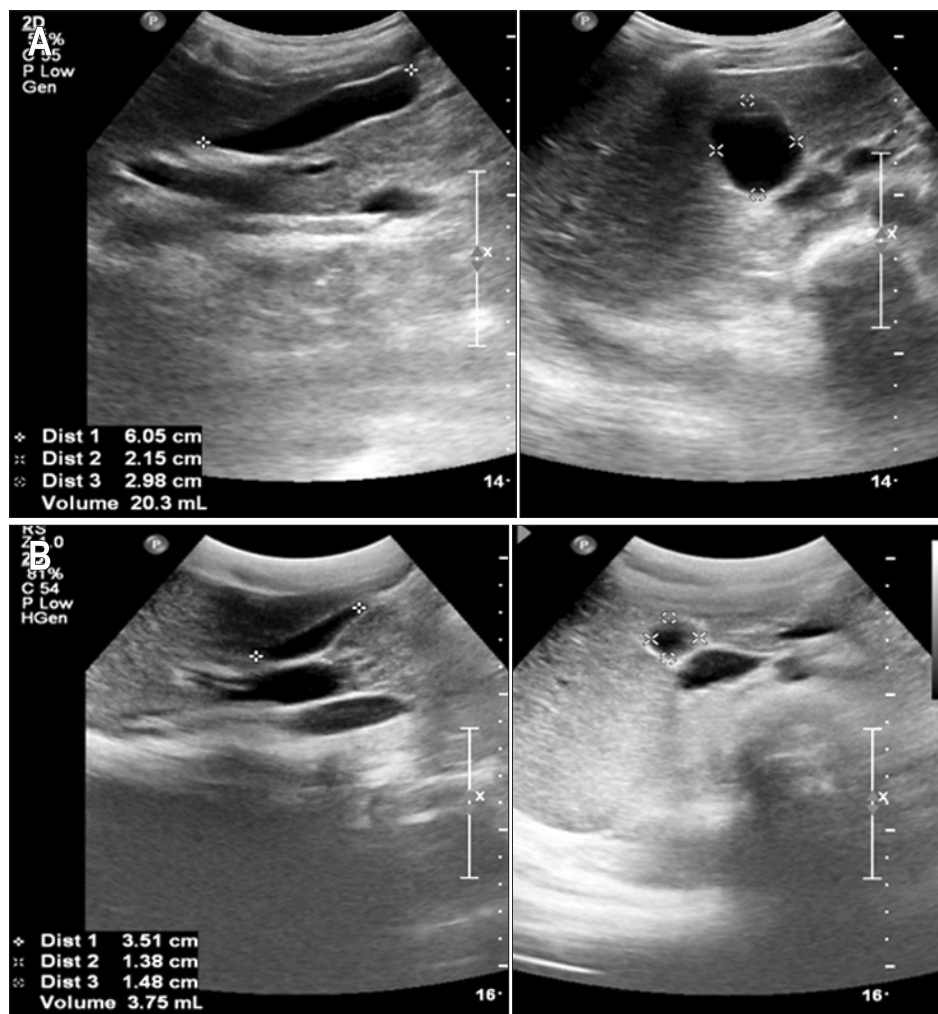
Ultrasound evaluation of gallbladder volume using Dodd's formula in the preprandial (A) and postprandial (B) states in a control child. Distances 1, 2, and 3 represent gallbladder length, width, and height, respectively. The contractility index was 68.8%.
